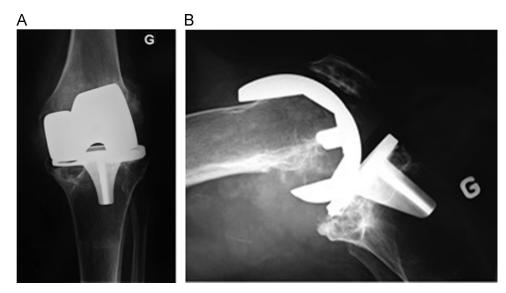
Preoperative AP and lateral radiographs of a knee with a loose tibial component and large metaphyseal defect.
